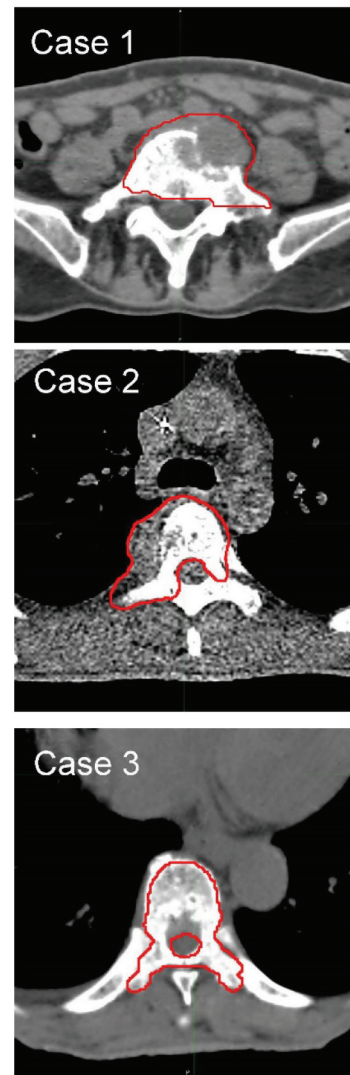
An axial CT image with clinical target volume (red line) for each case. Case 1, tumor at 5th lumbar spine; Case 2, tumor at 5th thoracic spine; Case 3, tumor at 10th thoracic spine.
